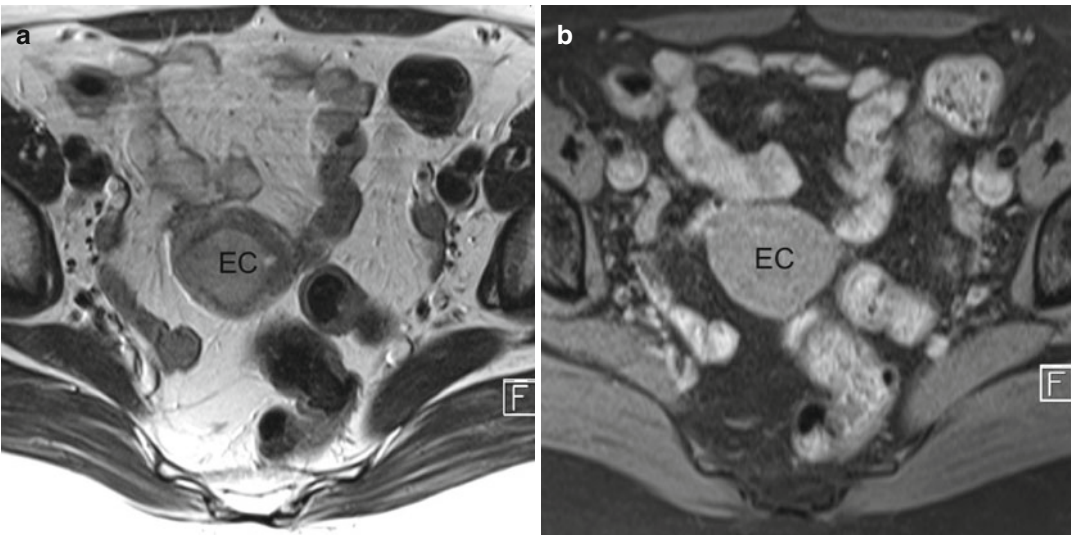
(a–e) Typical MRI features of endometrial carcinoma. Typically, endometrial carcinoma (*EC*) appears slightly hyperintense compared to the adjacent myometrium on T2-weighted images (TR/TE 2,400/76 ms) (a). On native T1-weighted images (TR/TE 730/10 ms) (b) endometrial carcinoma is not distinguishable from the normal uterine structures, whereas on post-contrast T1-weighted
